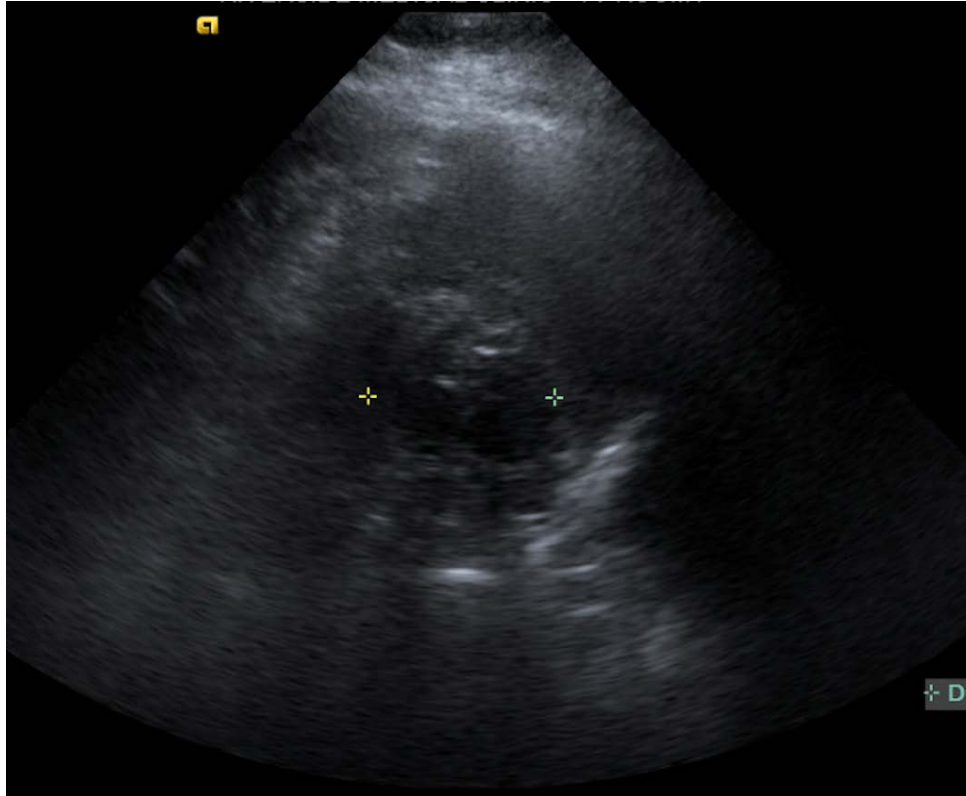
Ultrasound of splenic mass
